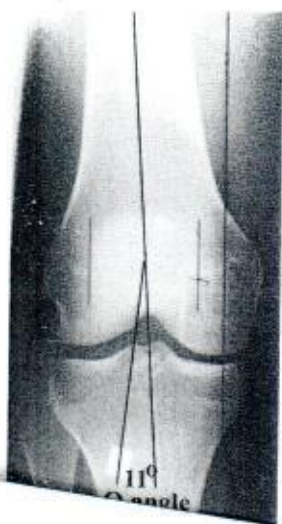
Measurement of the Q angle on a standing true anteroposterior radiograph of the knee in 10° of flexion. The femoral condyles were marked with lead
